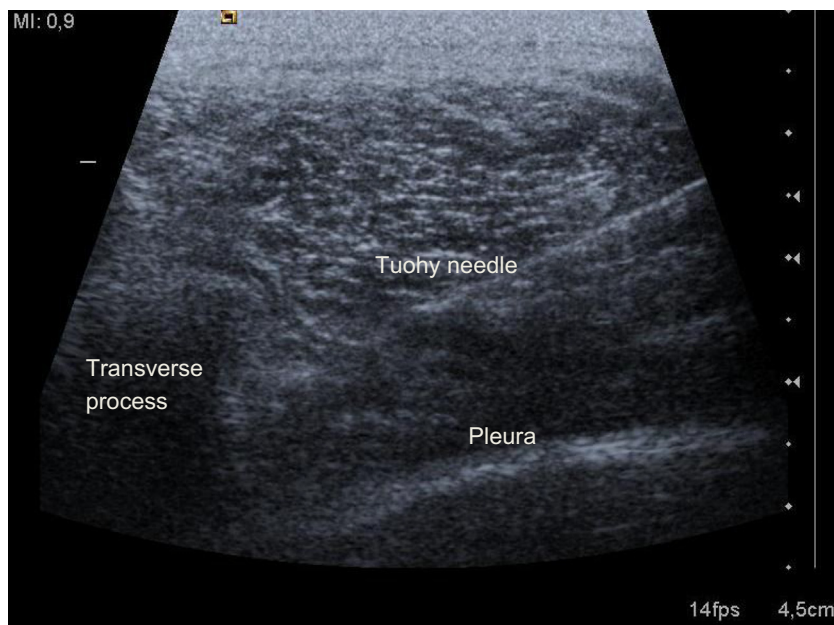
Ultrasound view of Tuohy needle while inserting the paravertebral catheter.
